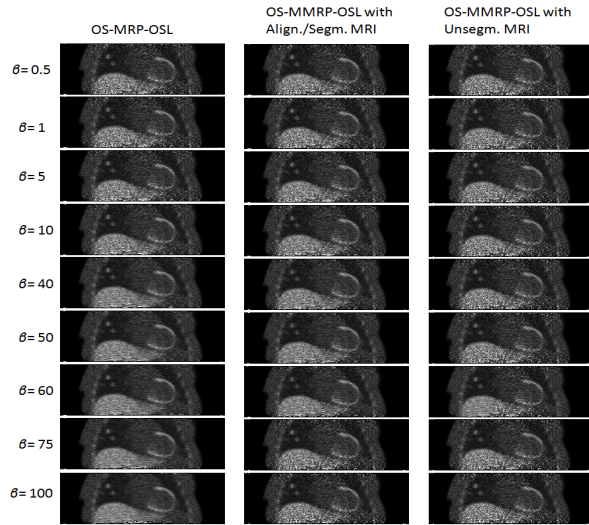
Coronal views of three algorithms after 15 iterations; OS-MRP-OSL (Left column). OS-MMRP-OSL using the perfectly aligned and segmented MR image (Middle column). OS-MMRP-OSL using the un-segmented MR image (Right column). Min=0, max=5.
